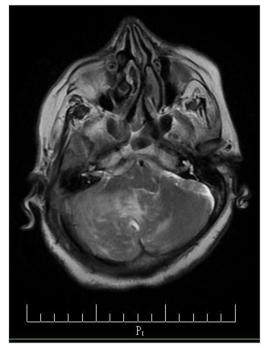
T2-weighted image. the mass was predominantly hyperintense and had hyper- and isointense striations with respect to gray matter.
